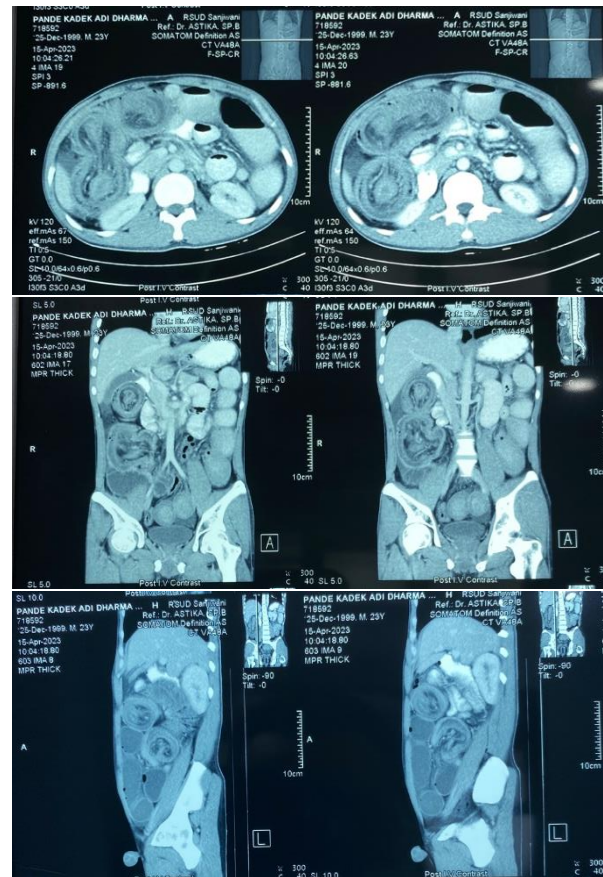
CT scan of the abdomen with contrast.
